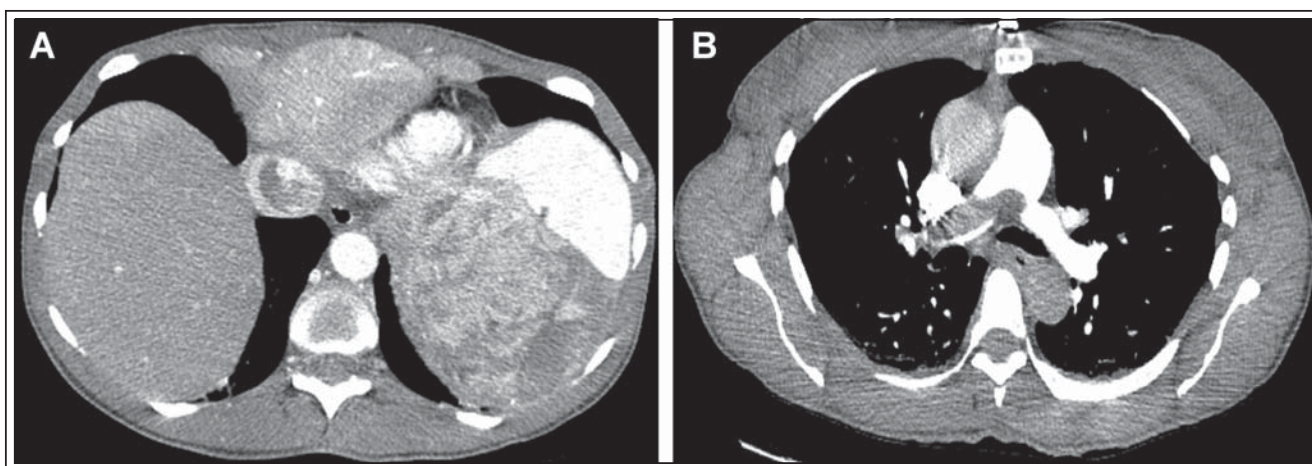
(a) CT scan showing a large left-sided adrenal mass with tumor thrombus in the inferior vena cava and (b) tumor embolus in the right pulmonary artery.
